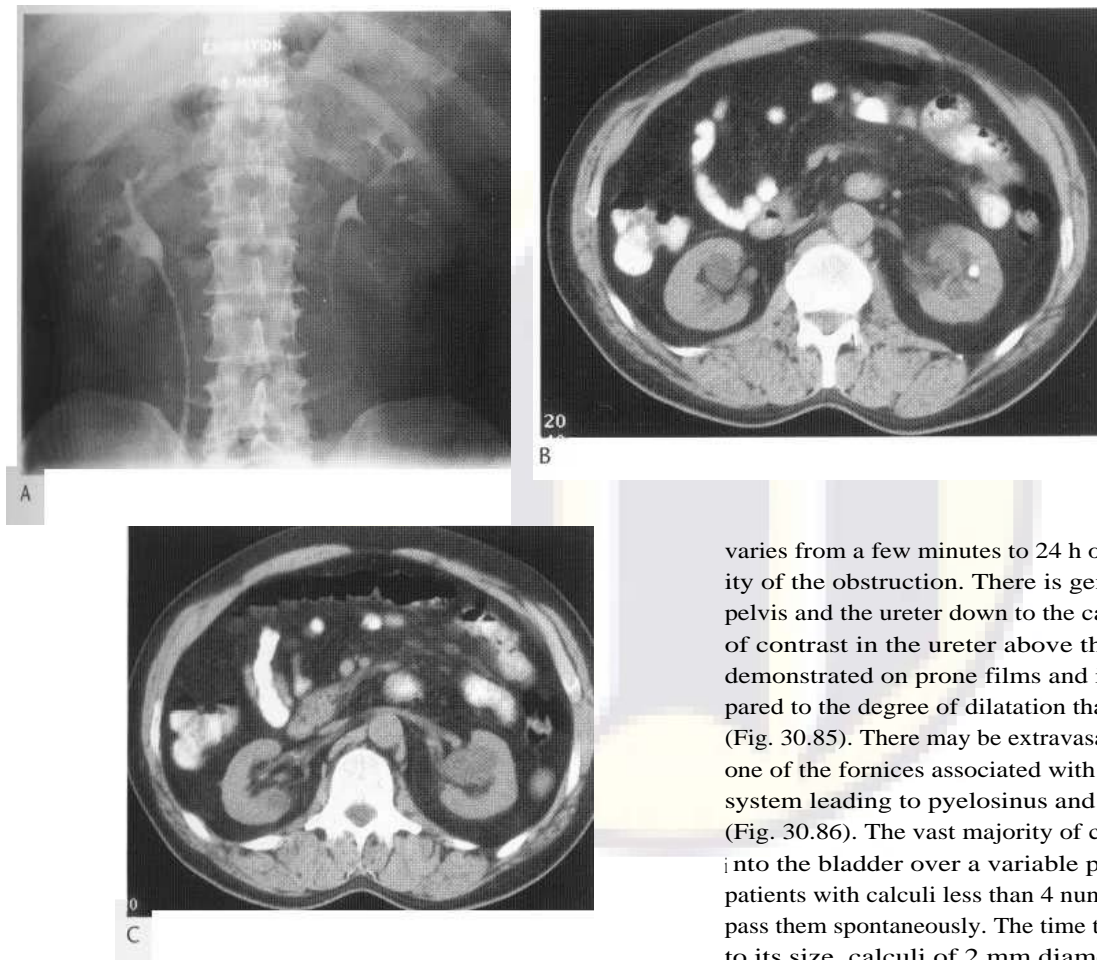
Radiolucent urate calculus, not visible on plain film, appearing as a well-defined filling defect in the collecting system of the left kidney (A). A larger mass is also visible distorting the left pelvicalyceal system. CT confirms that the small filling defect is a urate calculus (B) and the larger one a parapelvic cyst (C).
